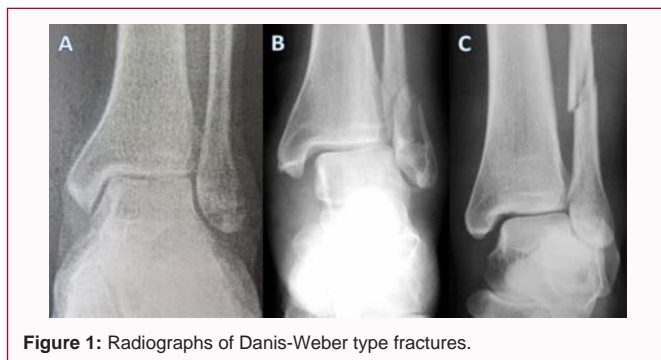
Radiographs of Danis-Weber type fractures.
